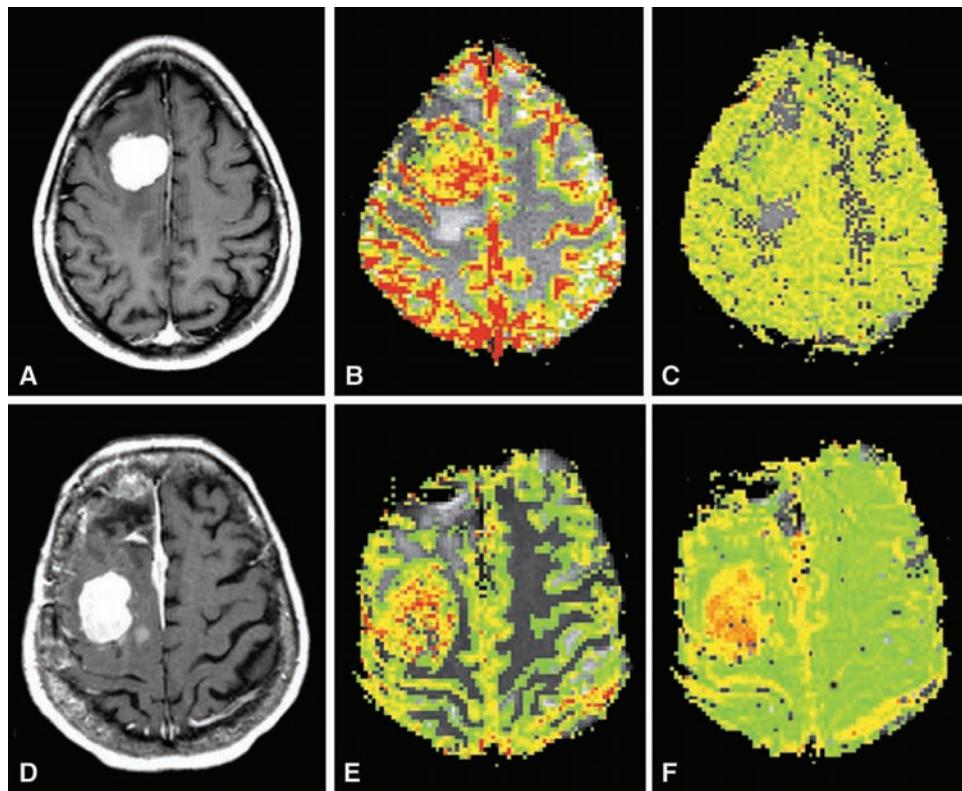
Pathologically confirmed meningioma, (WHO Grade I). (A) Axial T1-weighted postgadolinium image. (B) Gradient-echo axial DSC MRI with rCBV color overlay demonstrates high rCBV throughout the lesion. (C) Gradient-echo axial DSC MRI with SD25 color overlay depicts signal intensity drop after 25 seconds indicating mild increased vascular permeability. (D) Pathologically confirmed atypical meningioma, (WHO Grade II). Axial T1-weighted postgadolinium image. (E) Gradient-echo axial DSC MRI with rCBV color overlay demonstrates high rCBV throughout the lesion. (F) Gradient-echo axial DSC MRI with SD25 color overlay. Red indicates regions of highest signal drop, correlating to areas of marked increased vascular permeability. Qualitatively, this is the best way that this atypical meningioma can be differentiated from the typical meningioma seen in Figure 8 (C). Abbreviations: rCBV, relative cerebral blood volume; DSC MRI, dynamic susceptibility contrast MRI. Source: From Ref. 27.
